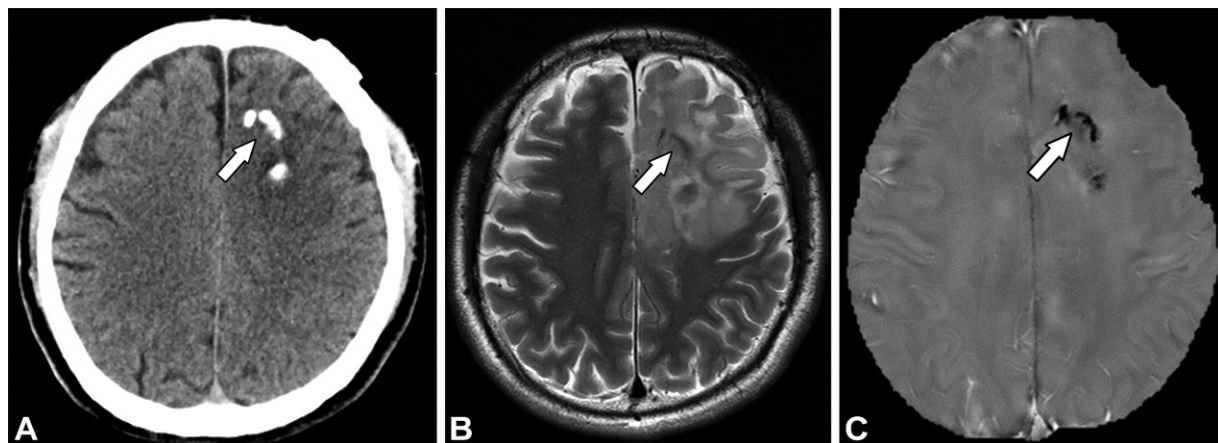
Oligodendroglioma in a 28-year-old man. (A) Axial CT image demonstrates a club-shaped calcification (arrow) in the left frontal lobe, which is a typical imaging finding in oligodendroglioma. (B) Axial T2*-weighted MR image shows faint low signal intensity (arrow) within the high signal intensity area. (C) QSM image demonstrates an area of definite low contrast (arrow), indicating calcification as a diamagnetic substance.
